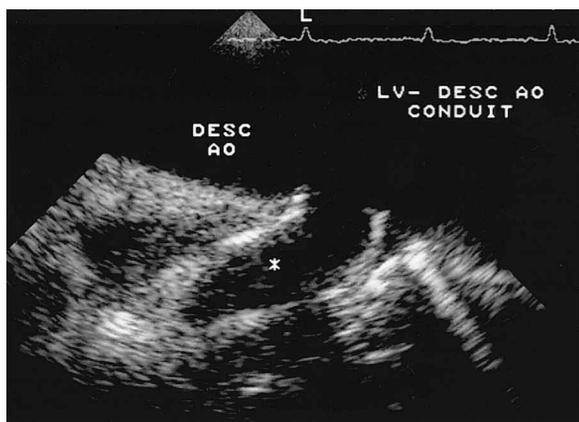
TEE at 90° demonstrates the conduit-descending aorta junction. TEE = transesophageal echocardiography.
